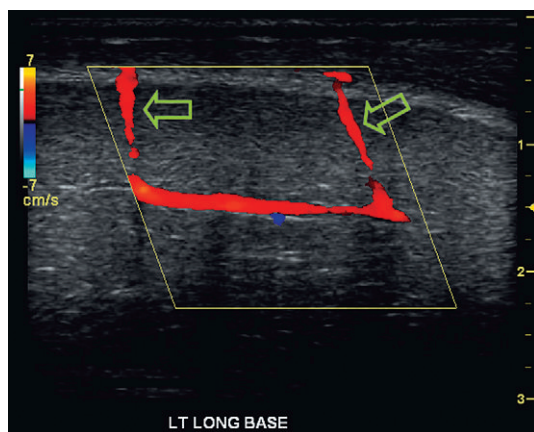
Longitudinal colour Doppler imaging. Note the presence of two dorsal–cavernosal perforating arteries (arrows).
